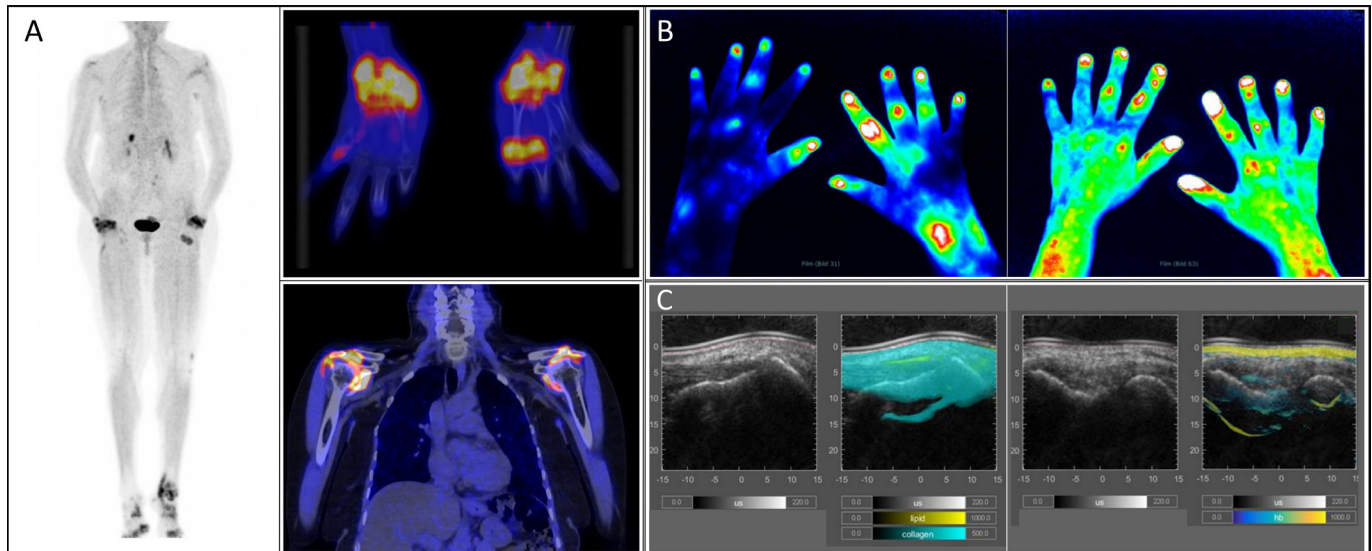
Examples of applied metabolic imaging to joints and entheses. Panel (A) ^{67}Ga -FAPI-04-positron emission tomography/CT scans showing avid intra-articular ^{67}Ga -FAPI uptake in the wrist, metacarpophalangeal and ankle joints (left and upper quadrant) and in the shoulder joints of patients with rheumatoid arthritis. Panel (B) fluorescence optical imaging acquisitions showing changes in micro vascularisation and increased blood flow in the finger joints of a patient with rheumatoid arthritis (left) and early psoriatic arthritis (right). Panel (C) multispectral optoacoustic tomography scans of the Achilles tendon enthesis (left) and of the lateral humeral epicondyle enthesis of a patient with psoriatic arthritis showing the distribution of lipid and collagen (left) and haemoglobin (right) superimposed to ultrasound. Ga-FAPI, ^{68}Ga -fibroblast activation protein inhibitor.
